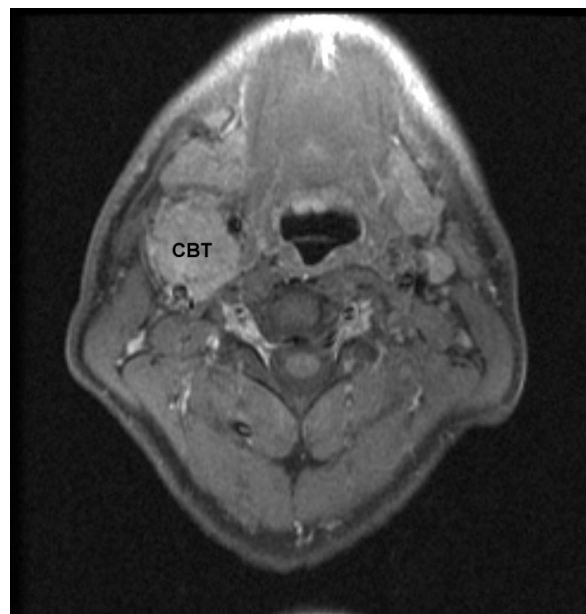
Carotid body tumour (CBT): MRI.
